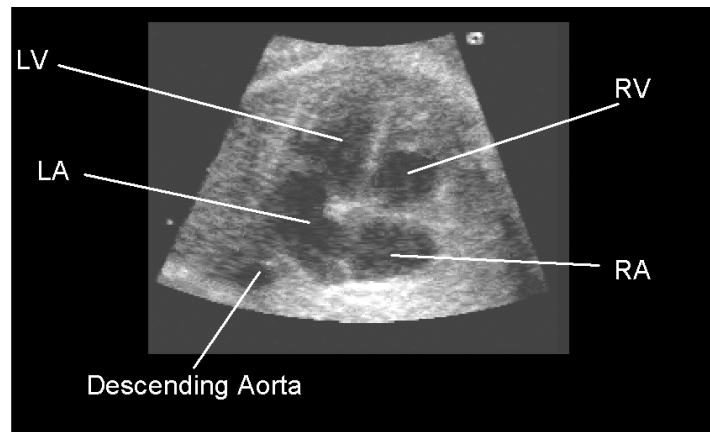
A slice showing the foetal heart in 4CV. The ventricles appear at the top of the image due to the orientation of the foetus in the uterus. The ultrasound probe would be at the top of this image in order to produce this view.
